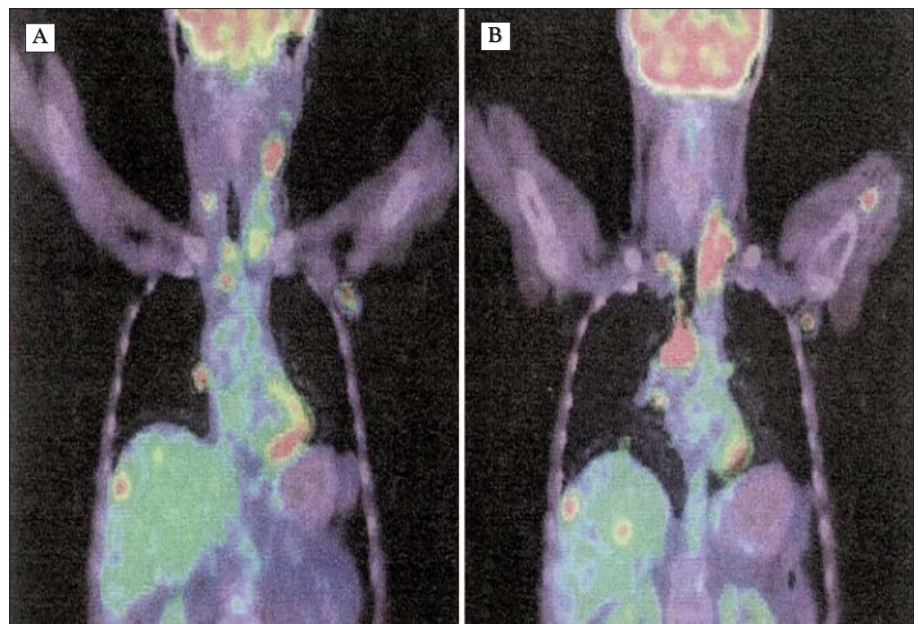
(A,B) FDG-PET scan: multiple lung, mediastinal, liver, and bone metastases
